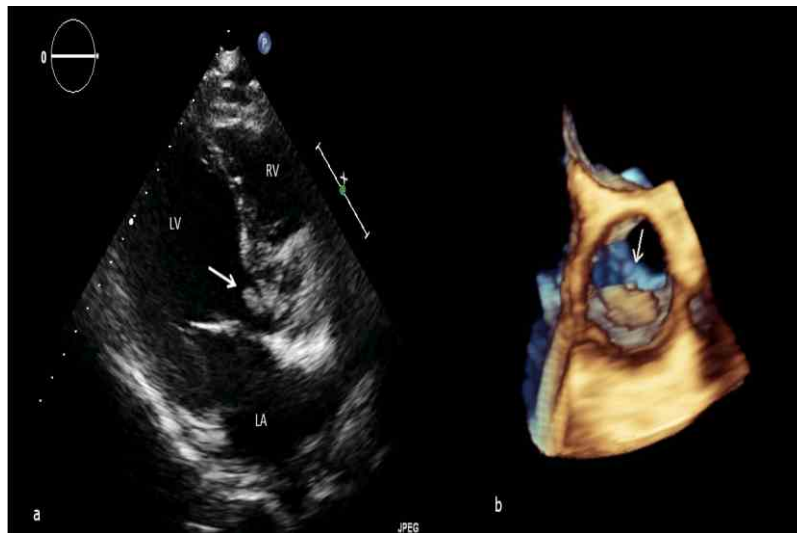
(a) Transthoracic parasternal long axis view showing an endocarditic mass (arrow) adherent on the ventricle side of the aortic cusp. LA: left atrium; LV: left ventricle; RV: right ventricle (b) Three-dimensional transesophageal echocardiogram (aortic view) showing the infectious mass adherent to the ventricular side of the right-coronary cusp and prolapsing in the aortic lumen during systole.
